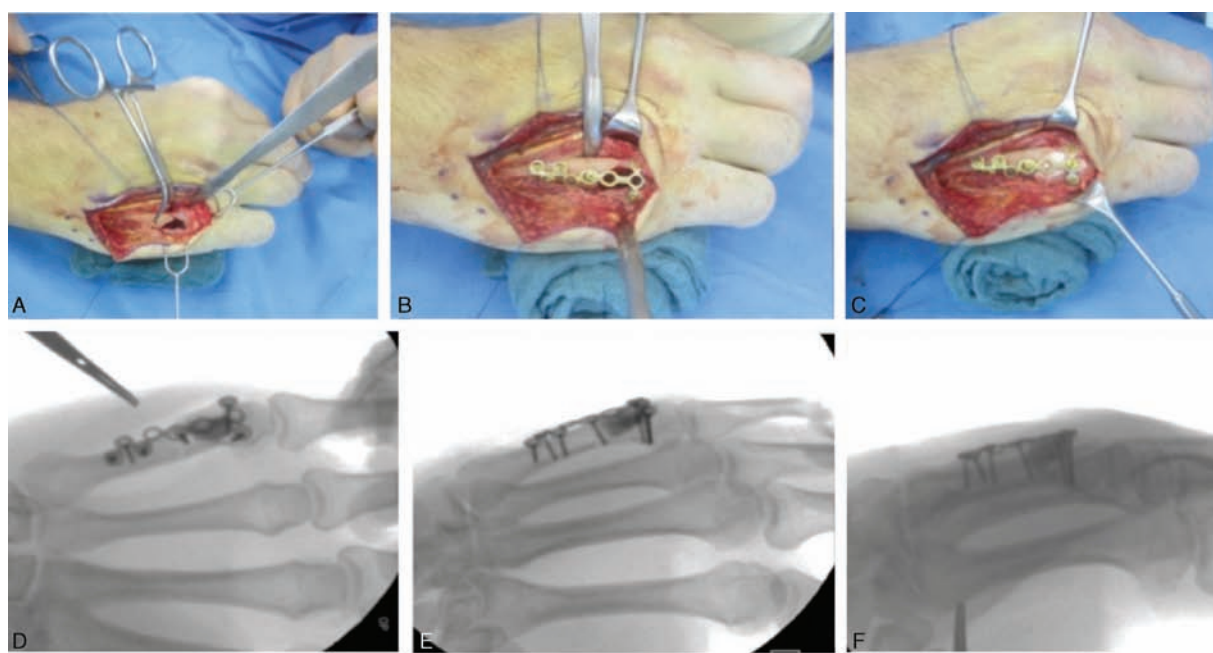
A dorsal approach was used (A) and initially the reduction of the fracture with placement of plate and screw followed (B). After the completion of the osteosynthesis, Cerament was injected into the defect zone (C). Intraoperative x-ray after open reduction and plate screw osteosynthesis, with Cerament, to treat this subcapital fifth metacarpal defect fracture.
